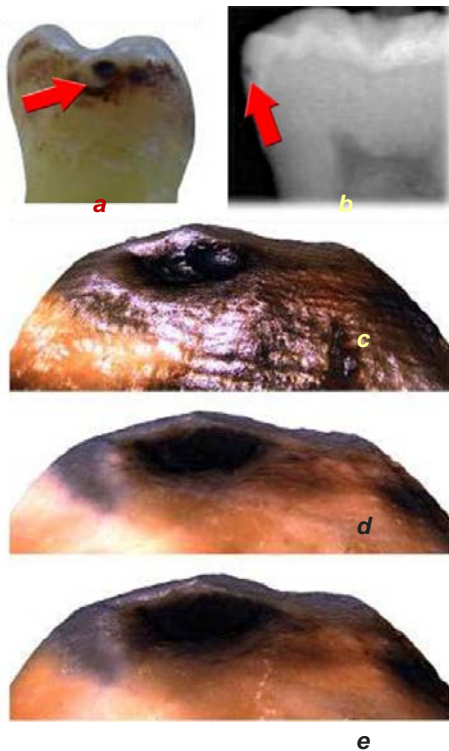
Macroscopic view (a) and respective radiograph (b) of inter-proximal caries (mandibular molar; R2 lesion). Longitudinal true color 3D imaging of untreated (c), etched (d), and infiltrated (e) lesion reveals a non-filled surface with a dished end (magnification 5×).
